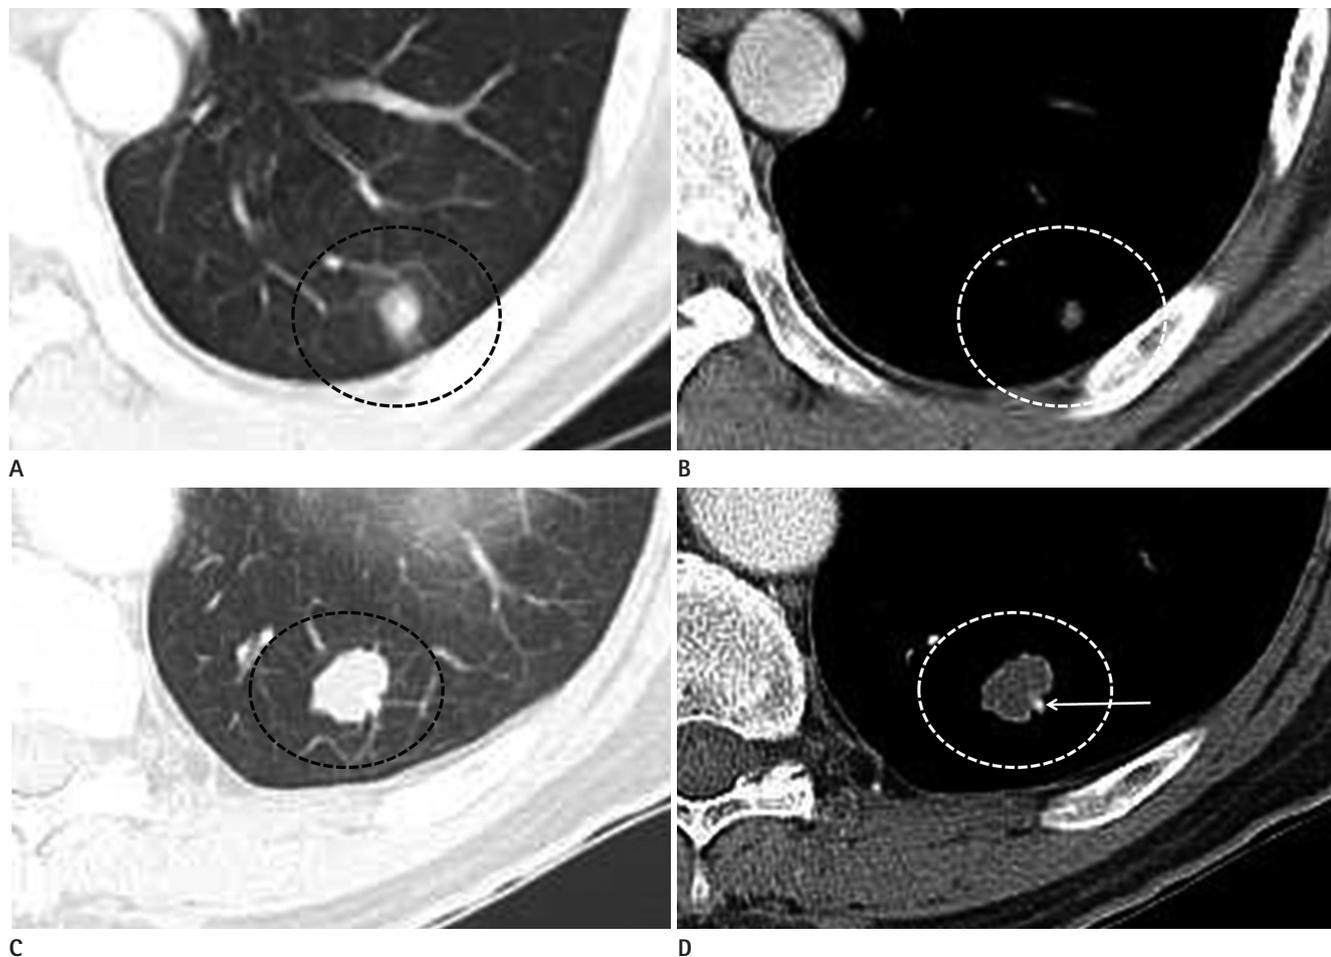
Chest CT scans of two patients who were considered to have pulmonary metastases. Chest CT scans with the lung (A) and mediastinum (B) setting of a 37-year-old man with rectal adenocarcinoma. A nodule (dotted circles) measuring about 0.9 cm in size without calcification was detected. Another nodule larger than 0.5 cm in diameter was also detected (not shown), and therefore, this patient was considered to have pulmonary metastasis. Chest CT scans with the lung (C) and mediastinum (D) setting of a 69-year-old man with rectal adenocarcinoma. A nodule (dotted circle) measuring about 1.9 cm in size without calcification in diameter is visible. The nodule was determined to be a metastatic lesion. The hyperdense dot beside the nodule (arrow) is a nearby enhanced pulmonary artery.
